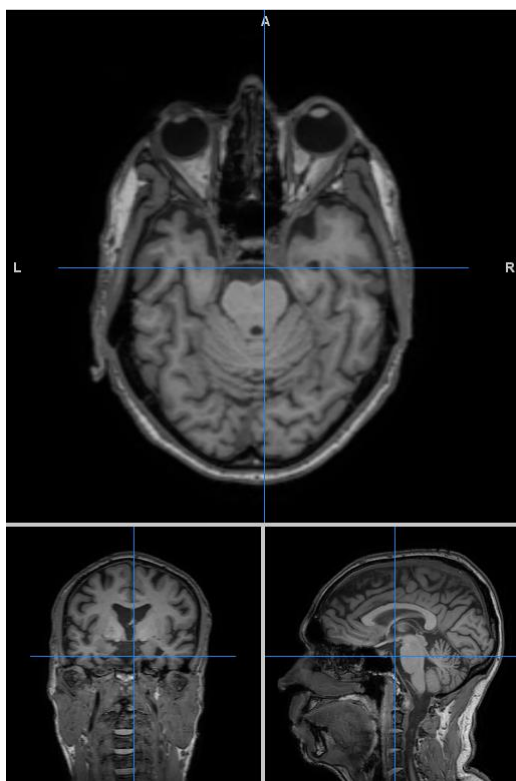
Original structural MRI image of AD subject 006_S_4153
